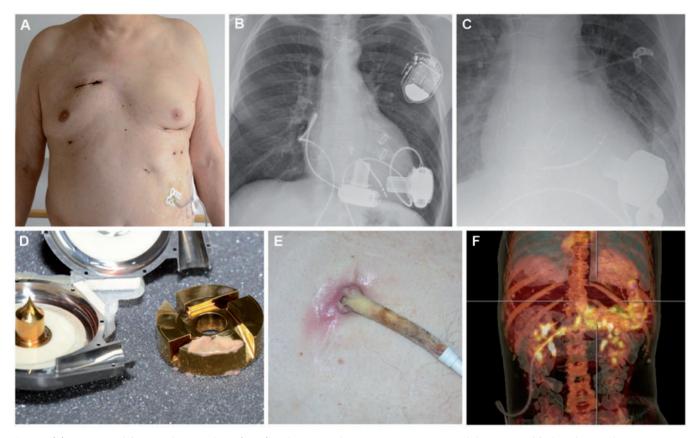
(A) Less invasive left ventricular assist device (LVAD) implantation techniques may preserve pericardial integrity and facilitate later median sternotomy in bridge to transplant patients. (B) Chest radiograph showing 2 centrifugal continuous flow pumps (HeartWare HVAD<sup>®</sup>, Medtronic, Minneapolis, MN, USA) for biventricular support. (C) A perfectly aligned inflow cannula of the Heartmate  $3^{®}$  within the inflow of the left ventricle and away from the septum may prevent low flow and pump thrombosis. (D) Pump thrombosis is a major complication in LVAD therapy. The image shows the impeller of an explanted HeartWare ventricular assist device with fibrin coating. (E) Peripheral driveline infections may be treated by antibiotic and local surgical means. (F) Positron emission tomography-computed tomography scans may uncover ascending infection of the LVAD, here a Heartmate II.
